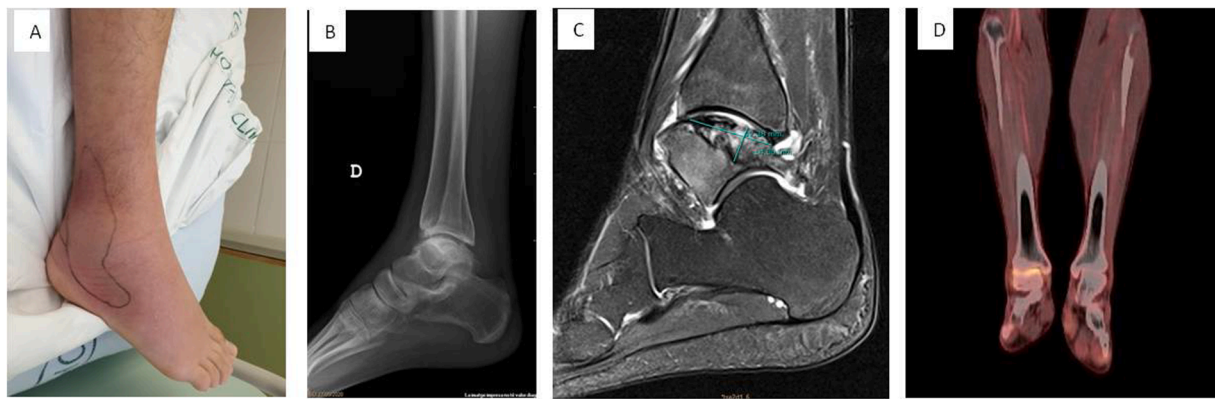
Case 5, Right ankle osteonecrosis. A. Clinical aspect, B. X rays, C. MRI, D. PET/CT scan.
